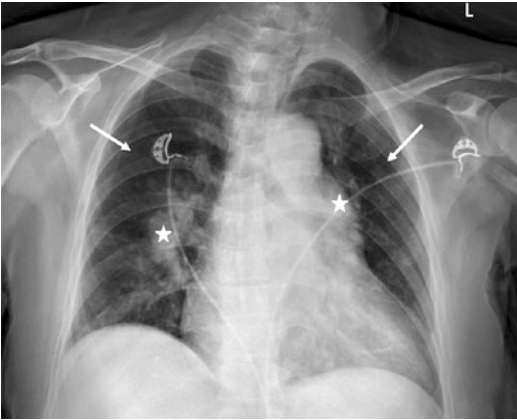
Pulmonary hypertension in a 64-year-old woman with history of chest discomfort after exertion for 4 years, and hypertension for 5 years. Chest radiograph shows prominent dilated pulmonary arteries (stars) with rapid pruning of peripheral pulmonary vessels (arrows), and cardiomegaly
